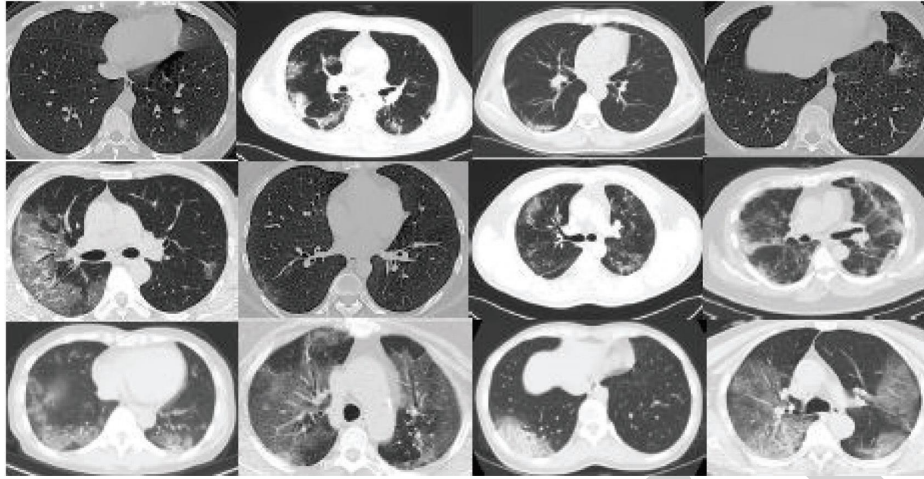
Positive cases for COVID-19 in CT scan images.
